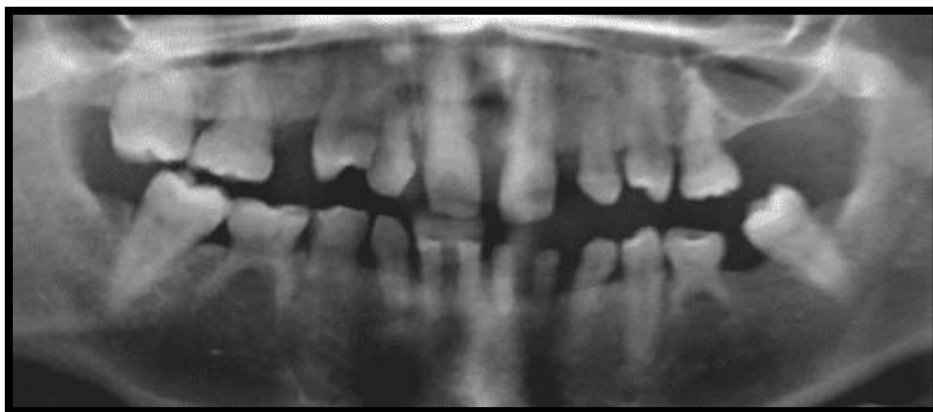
Radiography of nonsyndromic oligodontia patient (teeth missing: 12, 13, 15, 17, 18, 22, 23, 25, 26, 27, 28, 31, 32, 33, 35, 37, 38, 41, 42, 43, 44, 45, 47, 48) [21]
